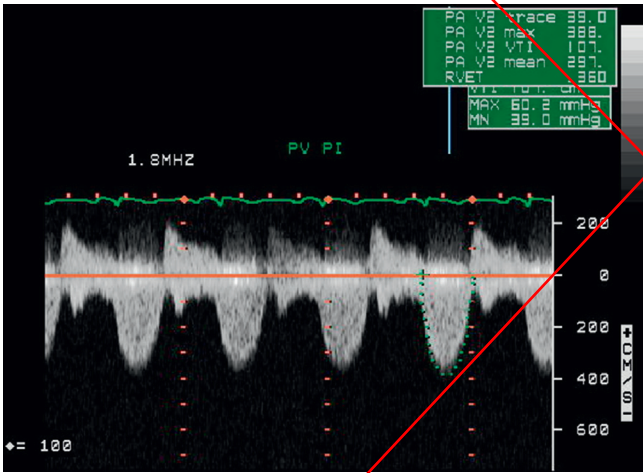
Spectral Doppler signal demonstrating severe pulmonic stenosis.
